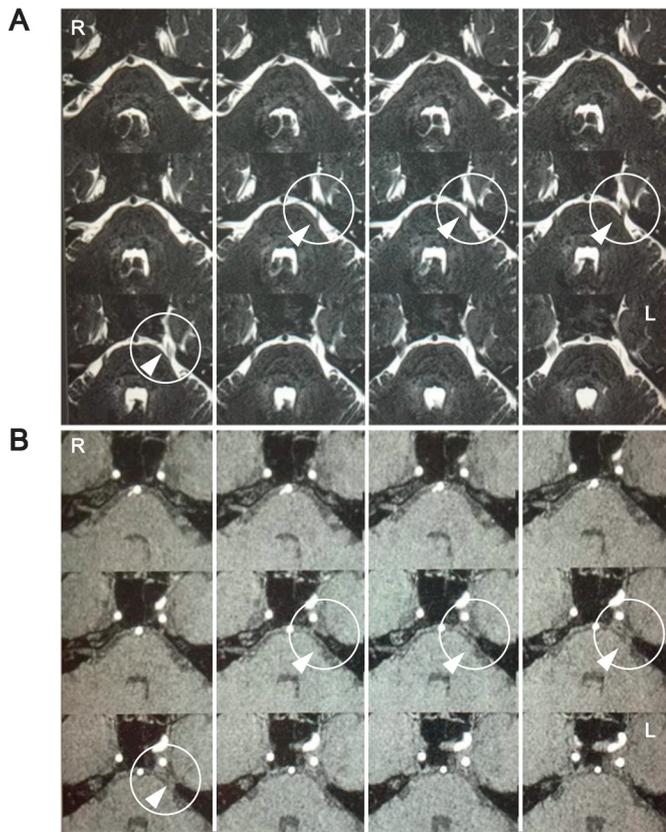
MRI of left trigeminal nerve. Arrowheads and circles indicate the trigeminal nerve. A: thin axial images of the CISS Drive. B: original thin axial images of the 3D TOF-MRA. MRI: magnetic resonance imaging, TOF: time-of-flight. MRA: magnetic resonance angiography.
